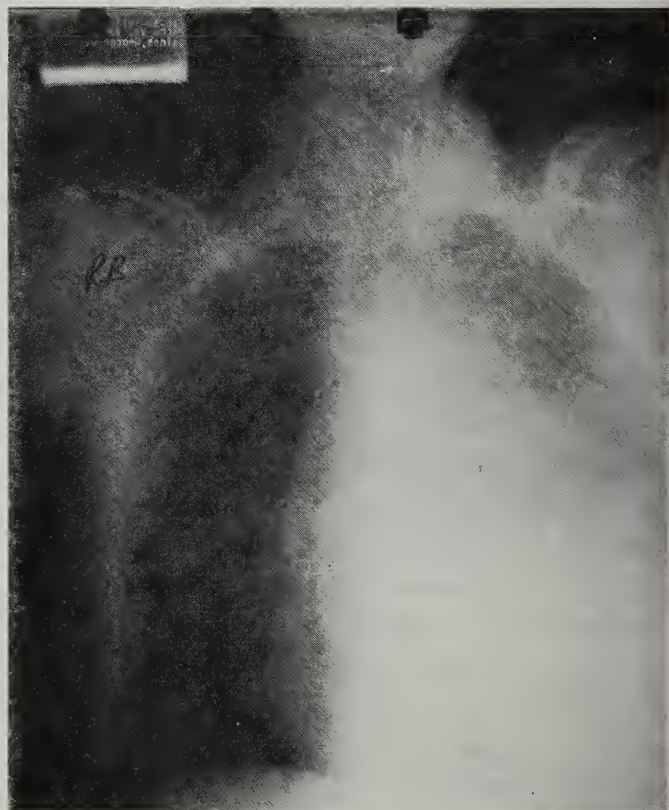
Chest x-ray showing large left pleural effusion.
